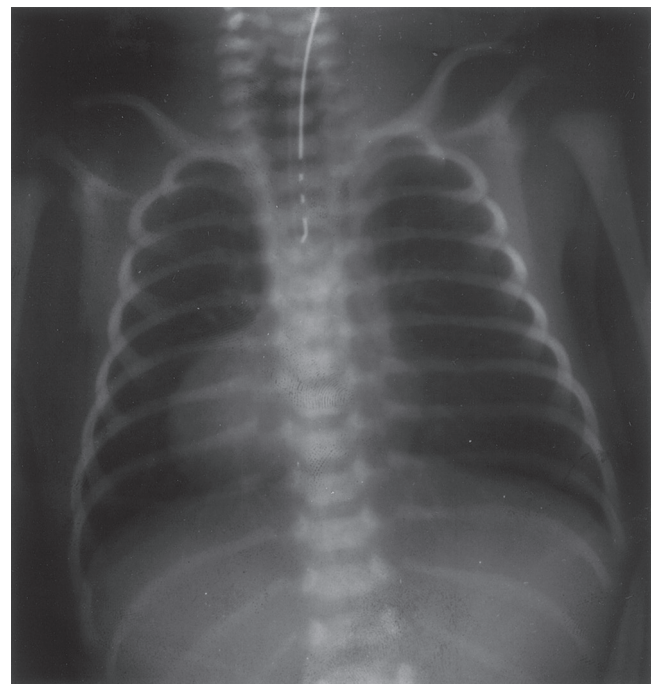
■ Chest radiograph of a patient with isolated esophageal atresia. Note the absence of air in the intestinal tract. (Courtesy Dr. C. Leftridge, Georgetown University Medical Center.)
